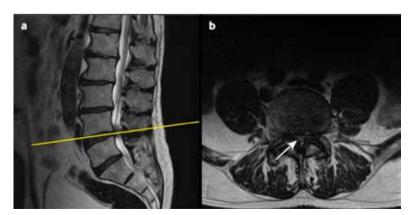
Lumbar spinal central stenosis on MRI. Sagittal (a) and axial (b) T2-weighted MRI of the L4/L5 lumbar segment of a 57 year old patient. The yellow line on image a indicates the level of the visual slice shown in image b. The images are showing limited space in the central spinal canal (arrow) owing to disc bulge, hypertrophy of the ligamentum flavum, and osteoarthrosis of the facet joints
